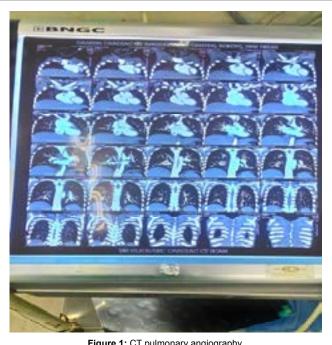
CT pulmonary angiography.
